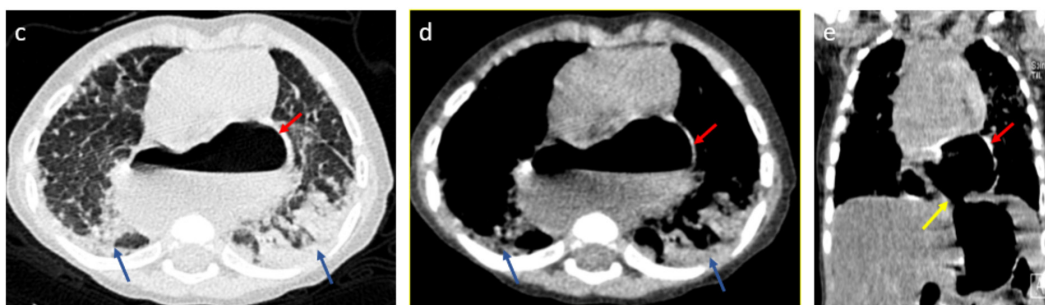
c-e. Herniated stomach (red arrows) in the retrocardiac area is observed in the axial lung (c) and mediastinal (d) windows in uncontrasted thorax computed tomography examination. In addition, diffuse fibroatelectasis densities are seen in the lower lobes of both lungs (blue arrows). Coronal reformat image (e) shows the presence of hiatal defect (yellow arrow) and herniation of the gastric fundus (red arrow)
